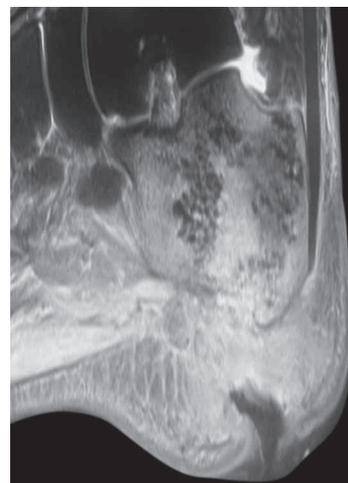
Preoperative MRI-sagittal view
